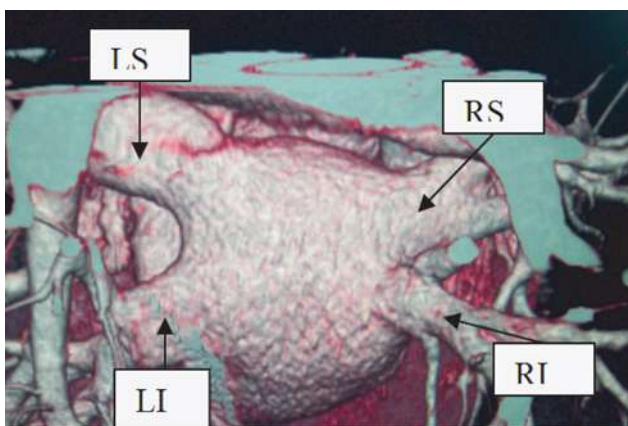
Evaluation of PVs by multisliced CT-scan (RS: right superior PV ; RI: right inferior PV; LS: left superior PV; LI: left inferior PV)
